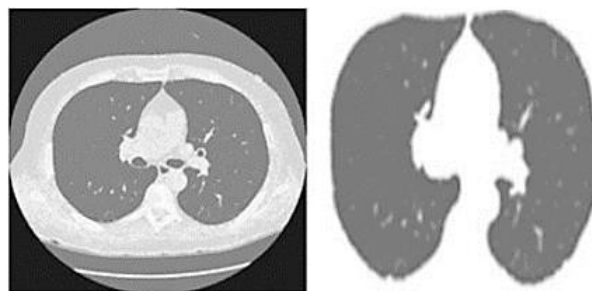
CT SCAN after Threshold Technique Applied
